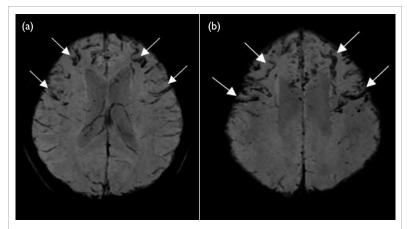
(a, b) Susceptibility-weighted sequences in follow-up magnetic resonance imaging of the brain revealed curvilinear blooming artifacts at cortices of bilateral frontal lobes, indicating development of cortical laminar necrosis (white arrows). This is associated with poor neurological prognosis due to irreversible damage
